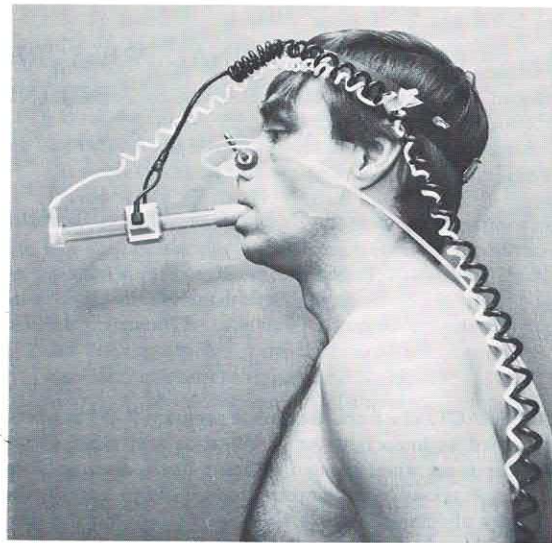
The respiration recording system. The ultrasound unit is located on the middle of the tube and the thermistor in the distal opening. Note the spring-holder on the nose and the catheters for the pressure recordings.
